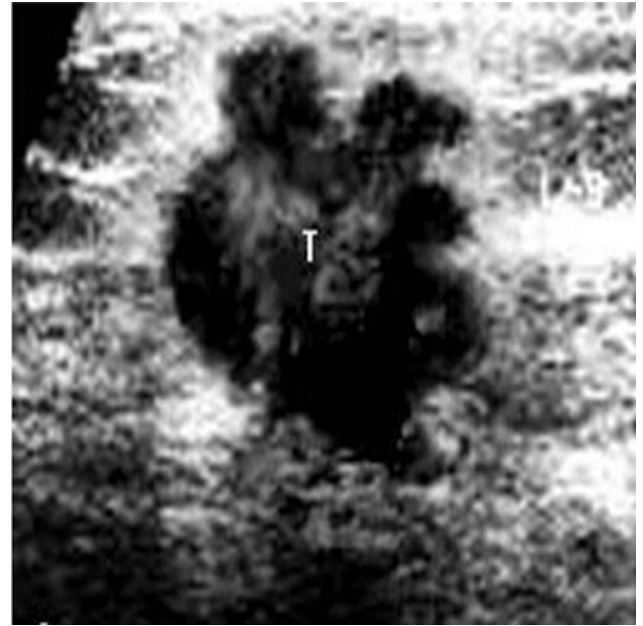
Malignant nodule by hand-held ultrasound.
